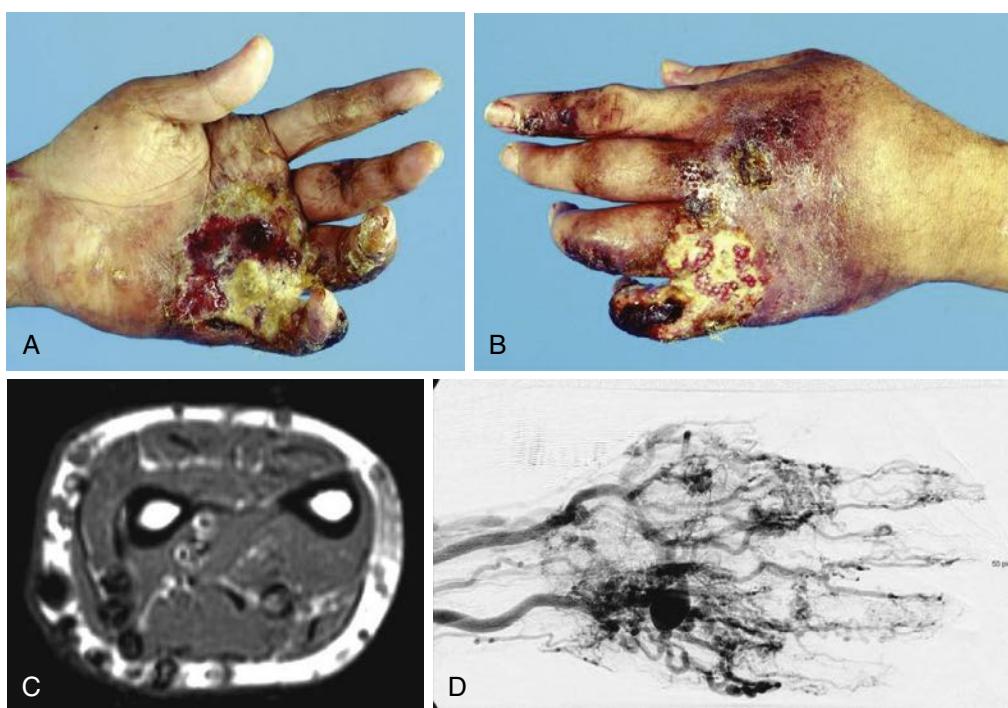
Natural course of arteriovenous malformation (AVM), with impending limb loss. (A, B) Ultimate outcome of a neglected AVM affecting the left hand and fingers. Stealing of arterial blood from the distal arterial trees by the AVM eventually leads to chronic arterial insufficiency and subsequent ischemia and gangrene. The hand and fingers are now in jeopardy, with great risk of major tissue loss. MRI (C) and arteriography (D) show evidence of massive shunting, making treatment more difficult.
